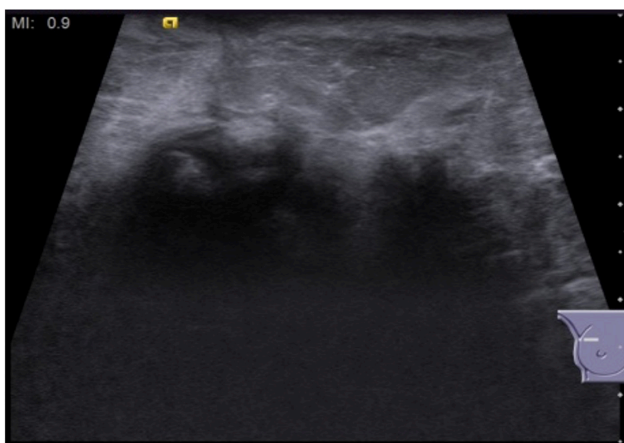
Early US image of a patient treated with IORT demonstrates a suspicious-looking ill-defined non-mass hypoechoic lesion at the operation site. IORT, intraoperative radiotherapy; US, ultrasound.
